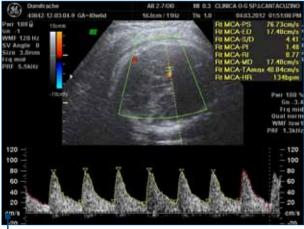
Doppler examination at 37 weeks with normal spectrum and parameters
